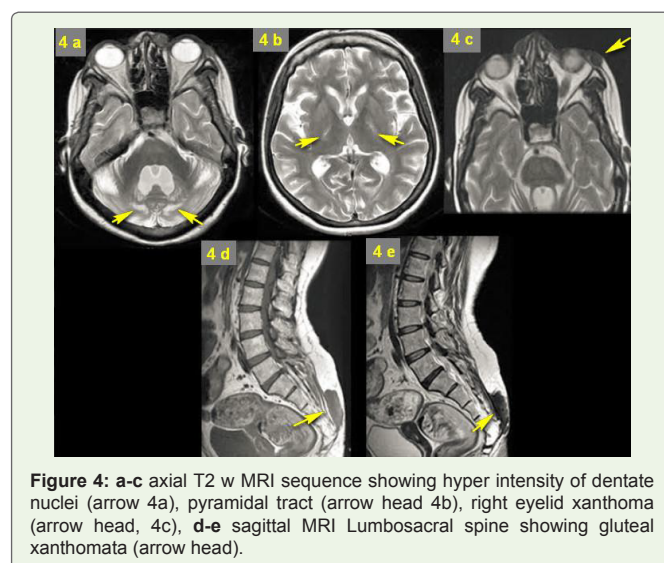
a-c axial T2 w MRI sequence showing hyper intensity of dentate nuclei (arrow 4a), pyramidal tract (arrow head 4b), right eyelid xanthoma (arrow head, 4c), d-e sagittal MRI Lumbosacral spine showing gluteal xanthomata (arrow head).
